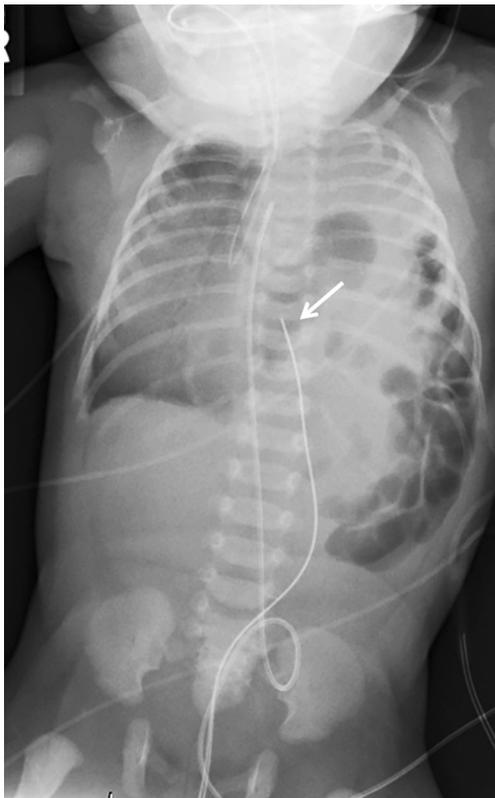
Anteroposterior radiograph of the chest and abdomen in a newborn girl. The radiology report excerpt was as follows: “A UVC catheter with tip projecting over the right heart border, and UAC catheter with tip projecting over T9 vertebral body are unchanged. An umbilical arterial catheter terminates at the level of T6.” The report did not specify the precise location of the UVC (umbilical venous catheter), which is suboptimal in the contralateral chest (*arrow*). In addition, the report excerpt is confusing, with mention of two umbilical arterial catheters (UACs), when in fact only one is present, terminating at the level of T5
